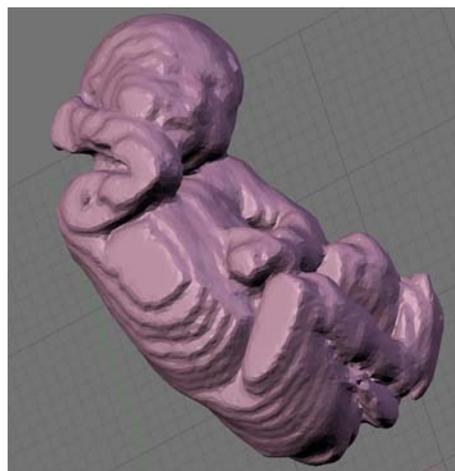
A 3D fetus shape, extracted from an MRI data set, with staircase effects
